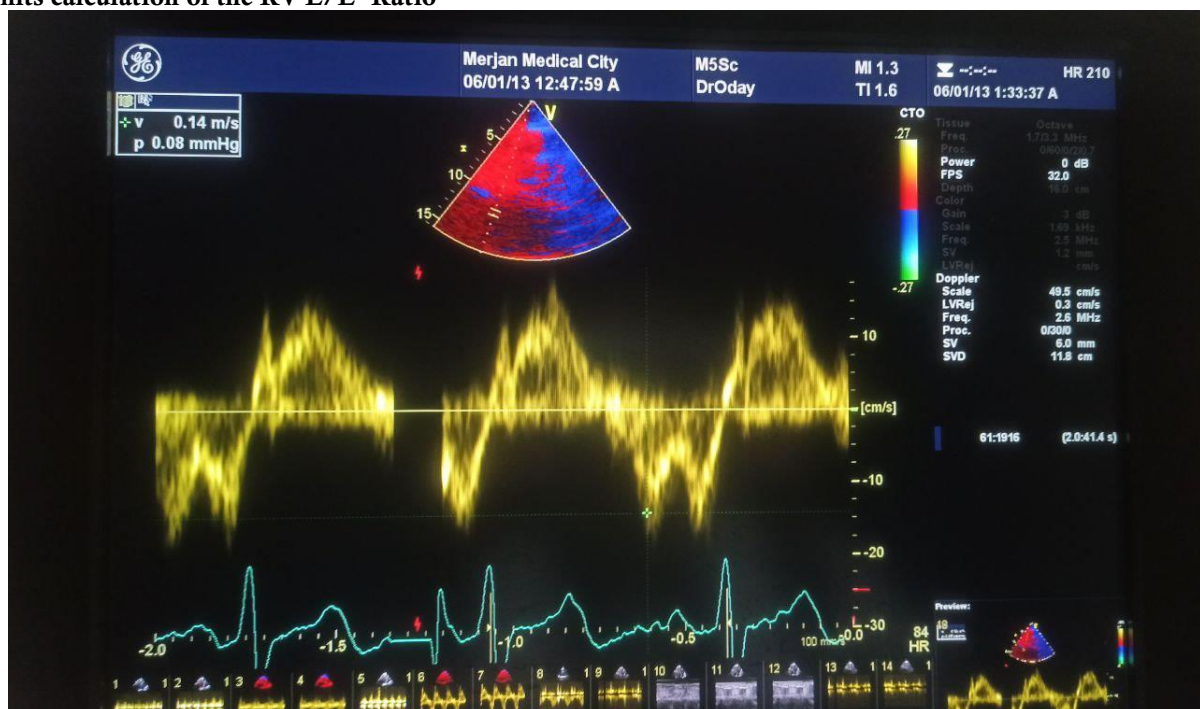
Pulsed tissue doppler imaging at the lateral annulus for measurement of E'
